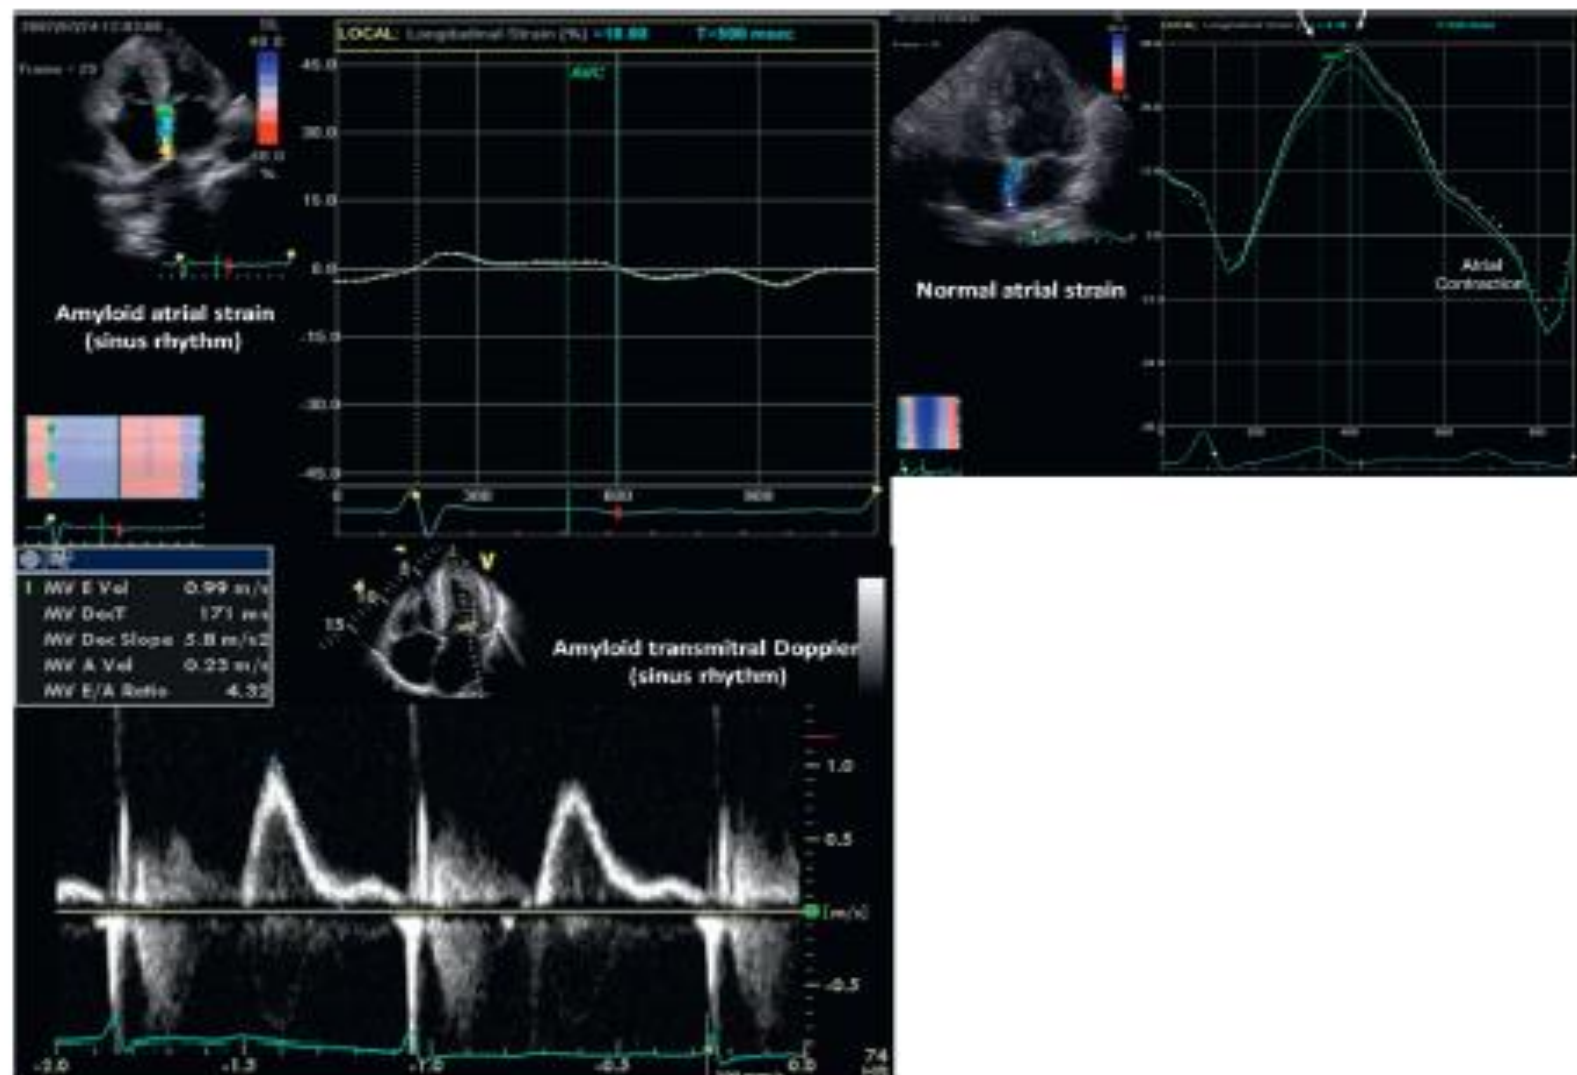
Typical Echocardiogram in AL Amyloidosis
